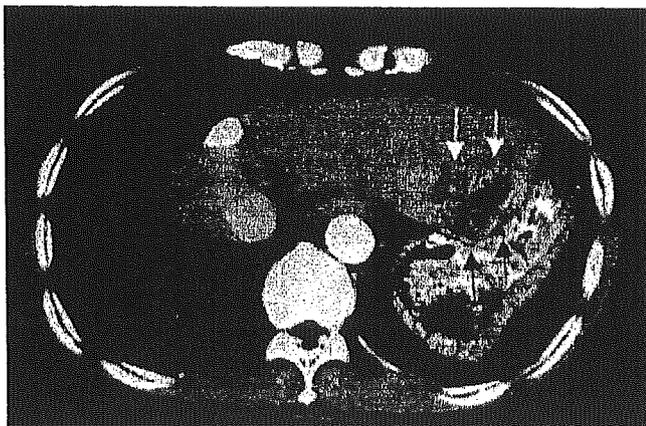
Abdominal CT revealed space-occupying lesions in the liver (white arrows) and direct invasion of hepatocellular carcinoma to the posterior gastric wall (black arrows).
